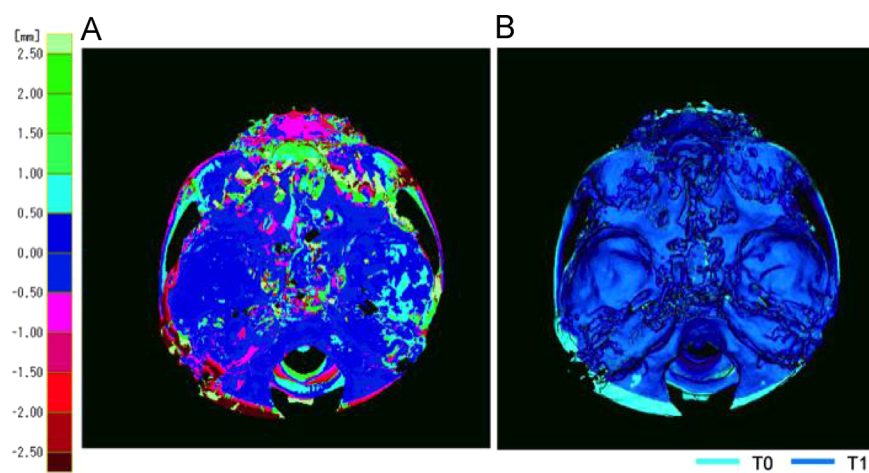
The iterative closest point (ICP) method. (A) Cranial base superimposition performed on all areas of the cranial base except the peripheral growing zone. (B) Merged image of pre-(T0) and post-treatment (T1) CBCT scans, superimposed at the cranial base.
